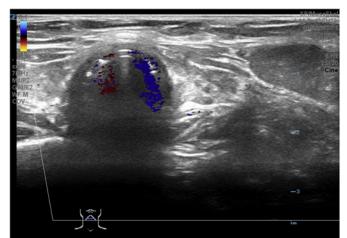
Tracheal intubation using color Doppler ultrasound.
